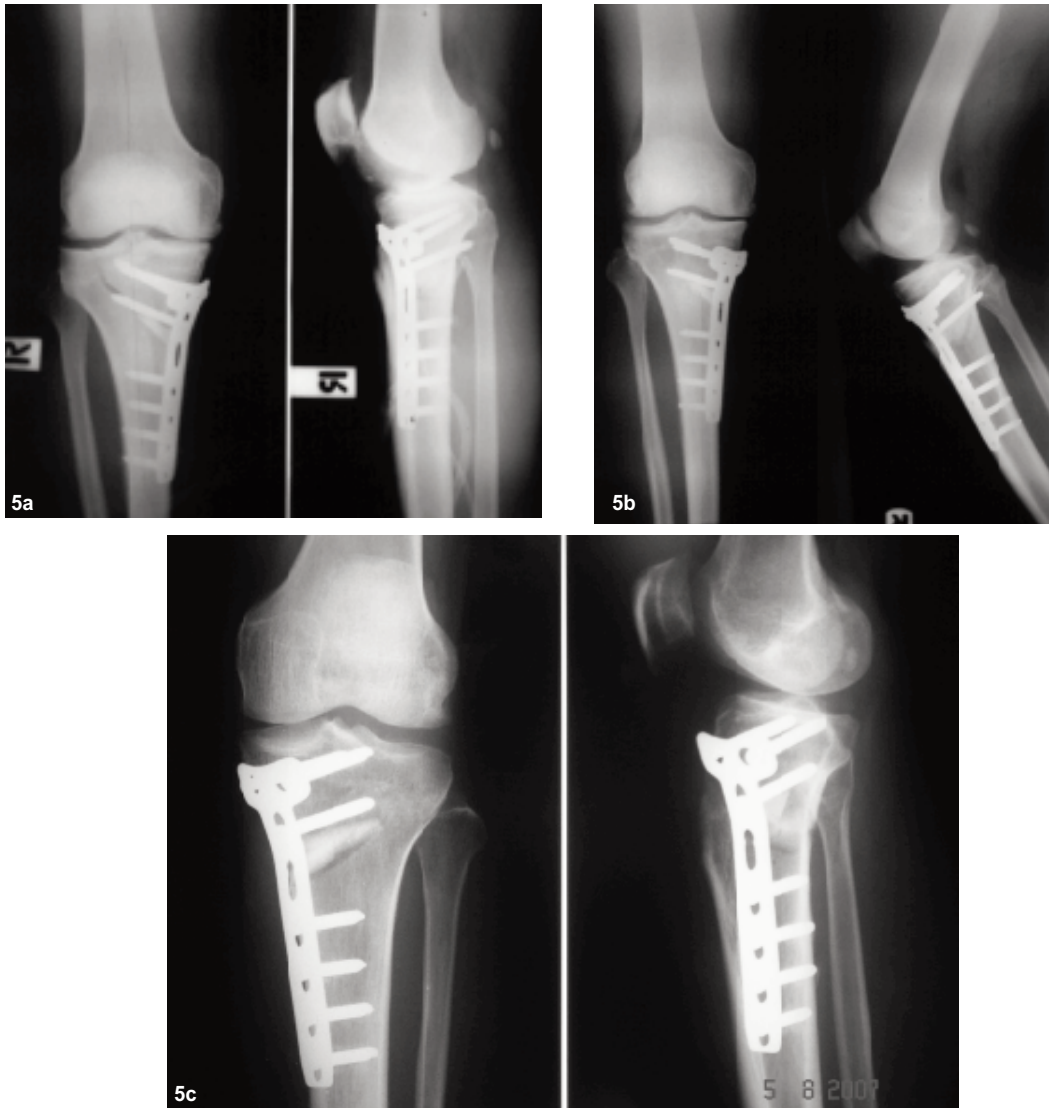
Intraoperative complications, an intra-articular fracture of the lateral tibial plateau was observed on a postoperative radiograph (Picture A), which delayed weight bearing. Ten week later, fracture had complete bony union and widening medial compartment on radiograph (Picture B). Postoperative radiography of a left knee 12 months postoperatively. Bony consolidation of the osteotomy gap with remodeling is visible (Picture C).
